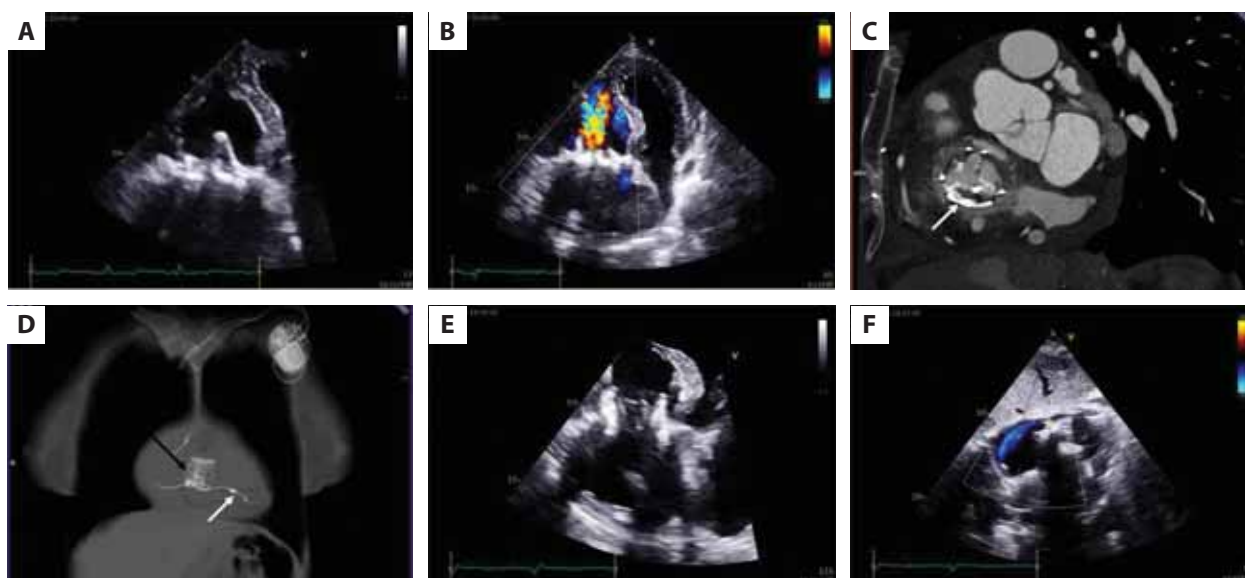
A. Transthoracic echocardiography. Four-chamber apical zoom view. Degenerated leaflets of the tricuspid bioprosthesis. B. Transthoracic echocardiography. Four-chamber apical view. Color Doppler flow. Turbulent flow through degenerated leaflets of the tricuspid bioprosthesis. C. Cardiac computed tomography. Multiplanar reconstruction, short-axis view. Bioprosthetic tricuspid valve degeneration (the arrow) — thickening and calcifications of the valve leaflets. D. Cardiac computed tomography after reimplantation of the tricuspid valve. Multiplanar reconstruction. Tricuspid valve bioprosthesis (the black arrow), pacemaker lead (the white arrow). E. Transthoracic echocardiography after the valve-in-valve procedure. Four-chamber apical zoom view. Correct position of the tricuspid valve-in-valve bioprosthesis. F. Transthoracic echocardiography after the valve-in-valve procedure. Substernal long-axis view. Color Doppler flow. Mild perivalvular leak in the lateral part of the tricuspid ring in the surrounding of the ventricular lead
